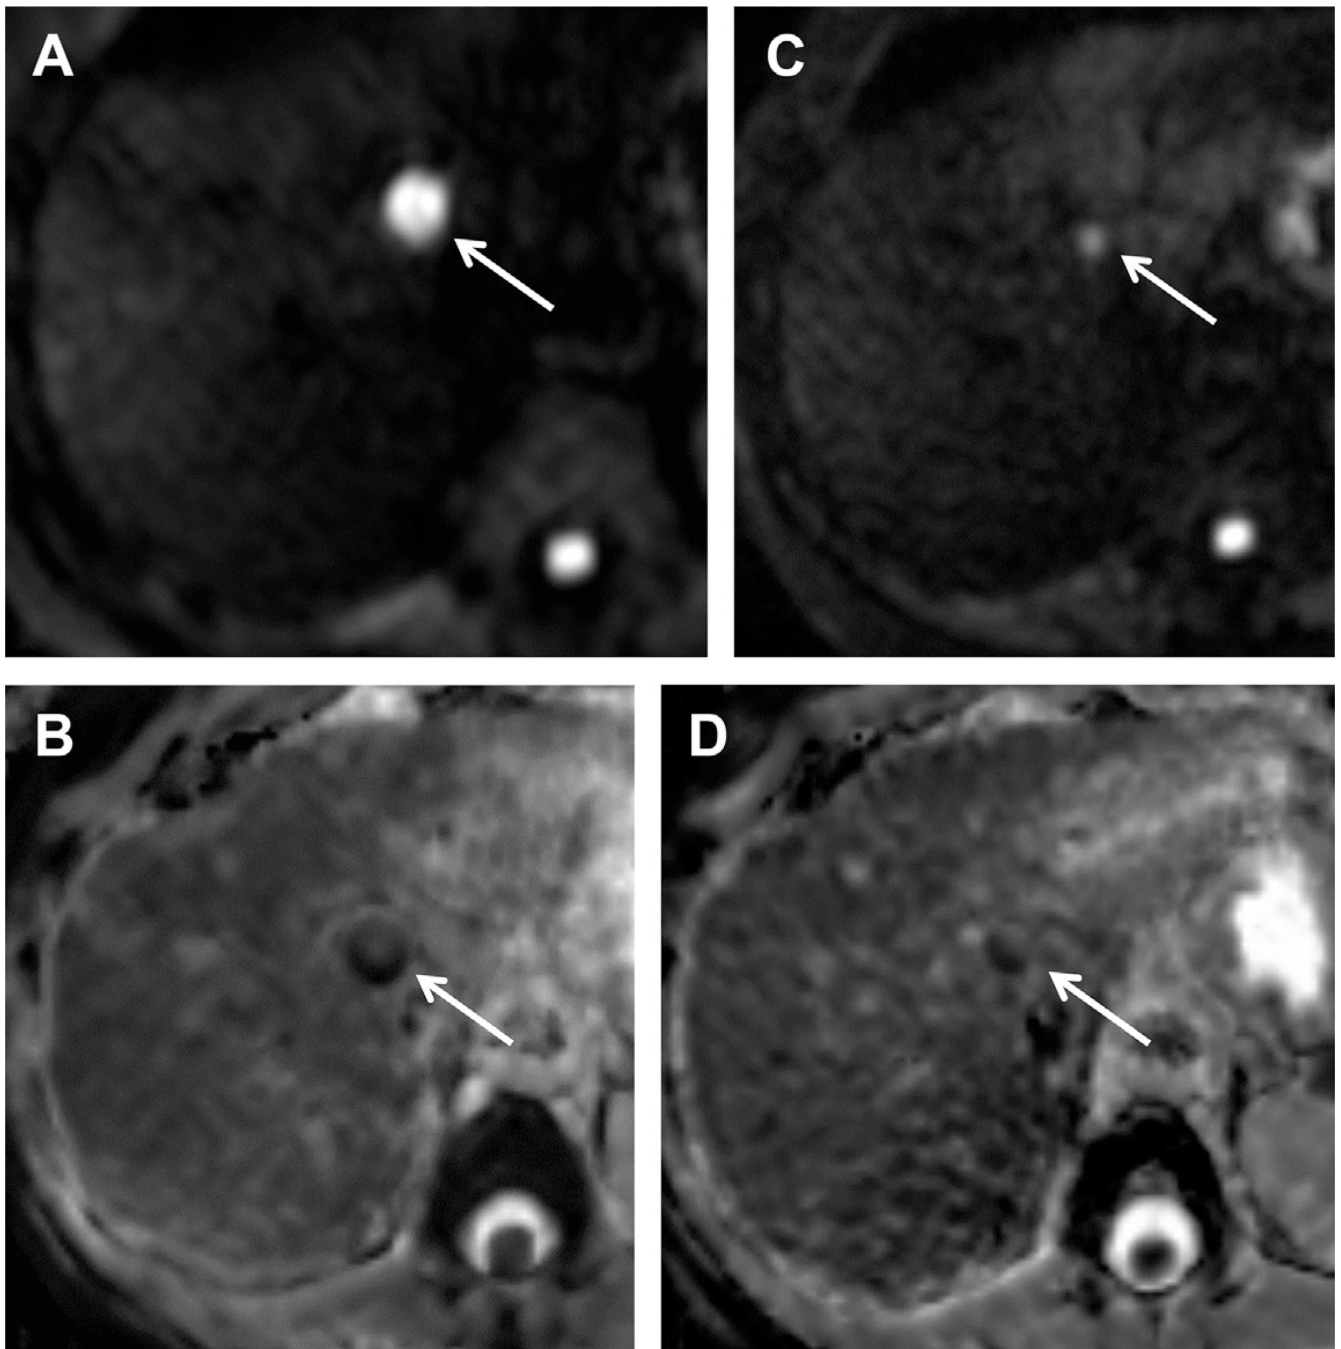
Therapy monitoring of breast cancer liver metastasis (*arrows*) with DWI. (*A, B*) Pretreatment DWI with b value of 900 s/mm^2 and corresponding ADC map show lesions with true restriction of water motion in segment IVa. ADC value: $0.48 \times 10^{-3} \text{ mm}^2/\text{s}$. (*C, D*) 4 months after chemotherapy DWI and ADC map demonstrate partial response with decrease in size and in SI in high b-value image, with increase in ADC value up to $1.1 \times 10^{-3} \text{ mm}^2/\text{s}$.
